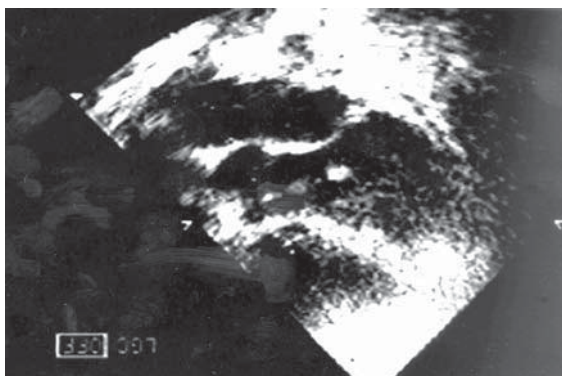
Transthoracic echocardiography demonstrates the echogenic mobile foreign body in the left ventricle extending to the aorta.
